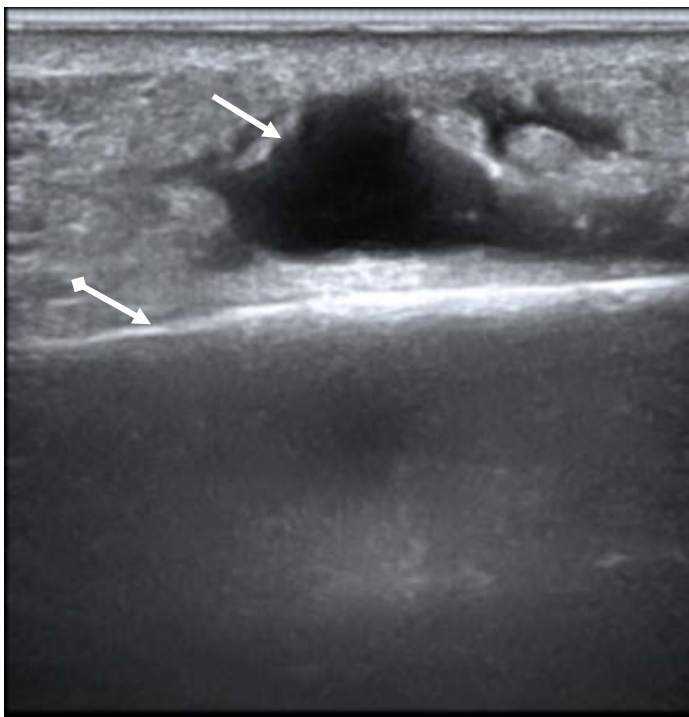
Ultrasound. B-mode.
